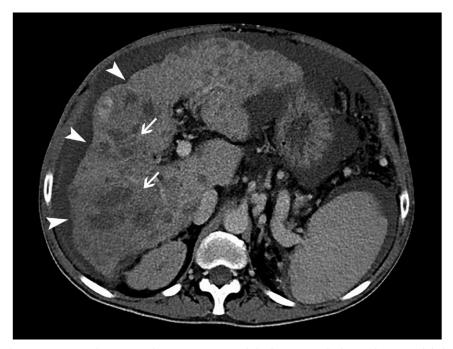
Contrast abdomen computed tomography scan one month before tumor lysis syndrome; axial view. Wavy nodular liver margins (arrowheads) and poorly defined extensively infiltrative masses (thin arrows).
